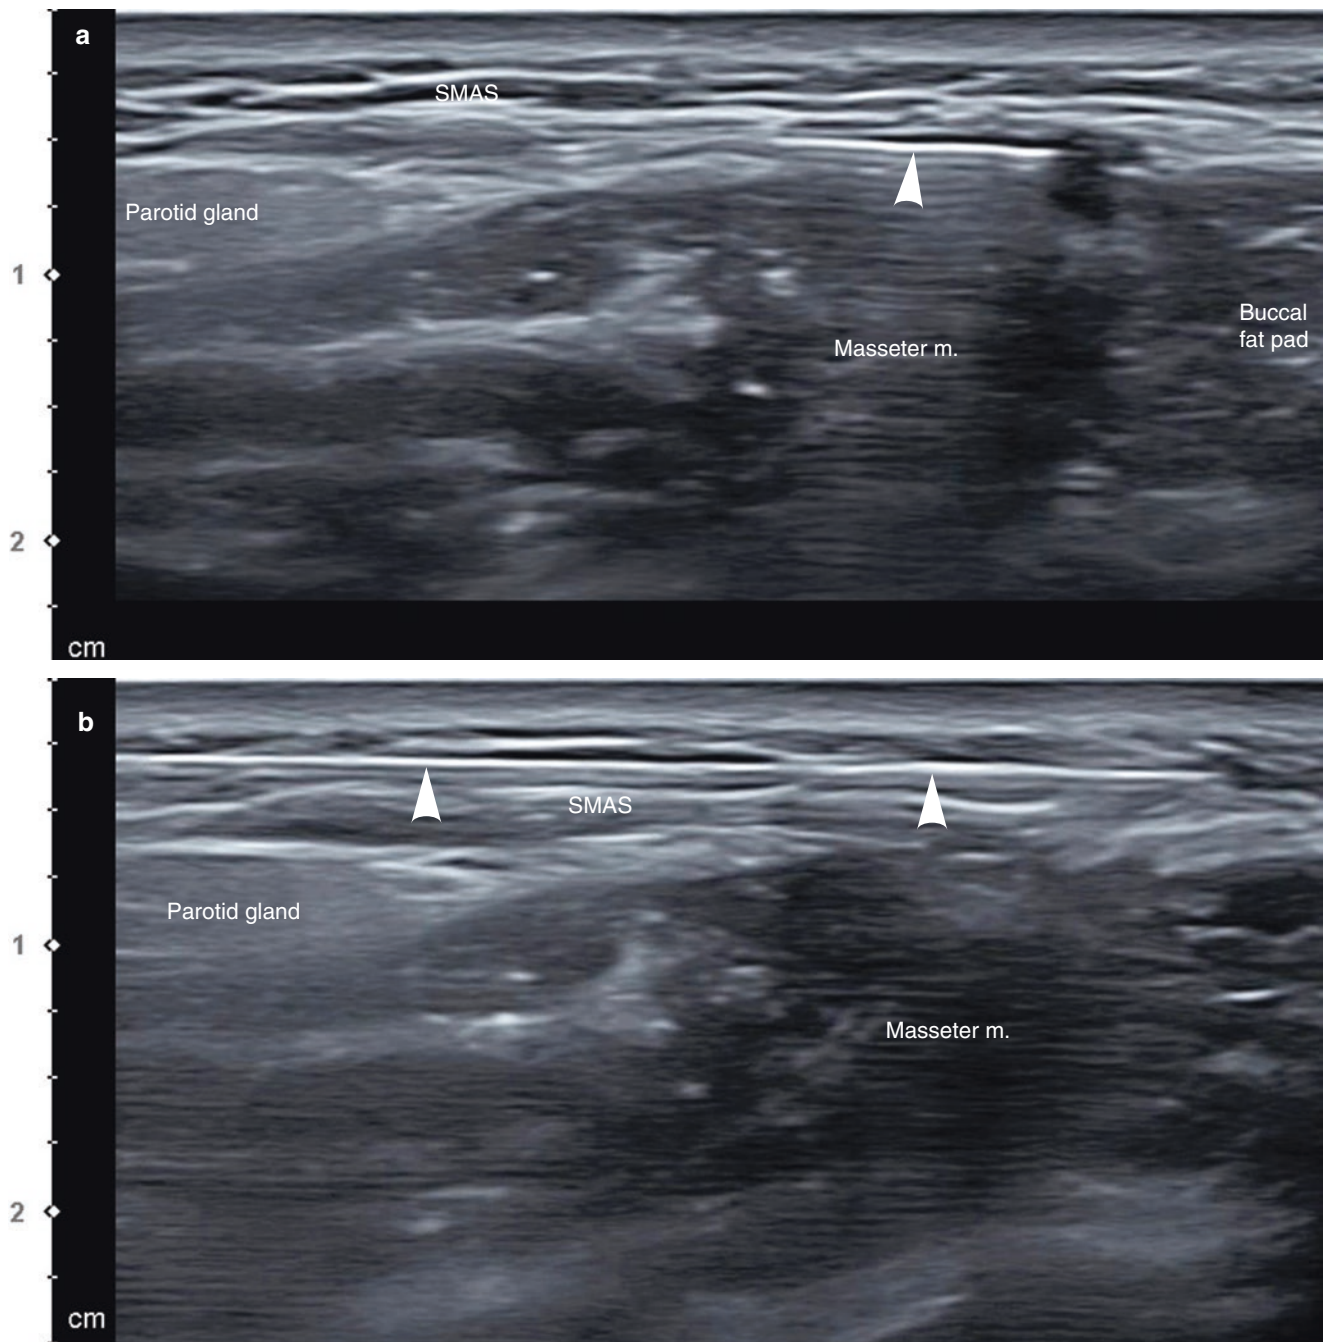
Ultrasonography-guided multidirectional cog thread cannula insertion for oblique lift. (a) Below the SMAS, B mode (oblique view, 15 MHz by linear transducer) and (b) above the SMAS, B mode (oblique view, 15 MHz by linear transducer) (arrowheads: thread cannula). (Published with kind permission of © Ji-Soo Kim 2020. All Rights Reserved)
